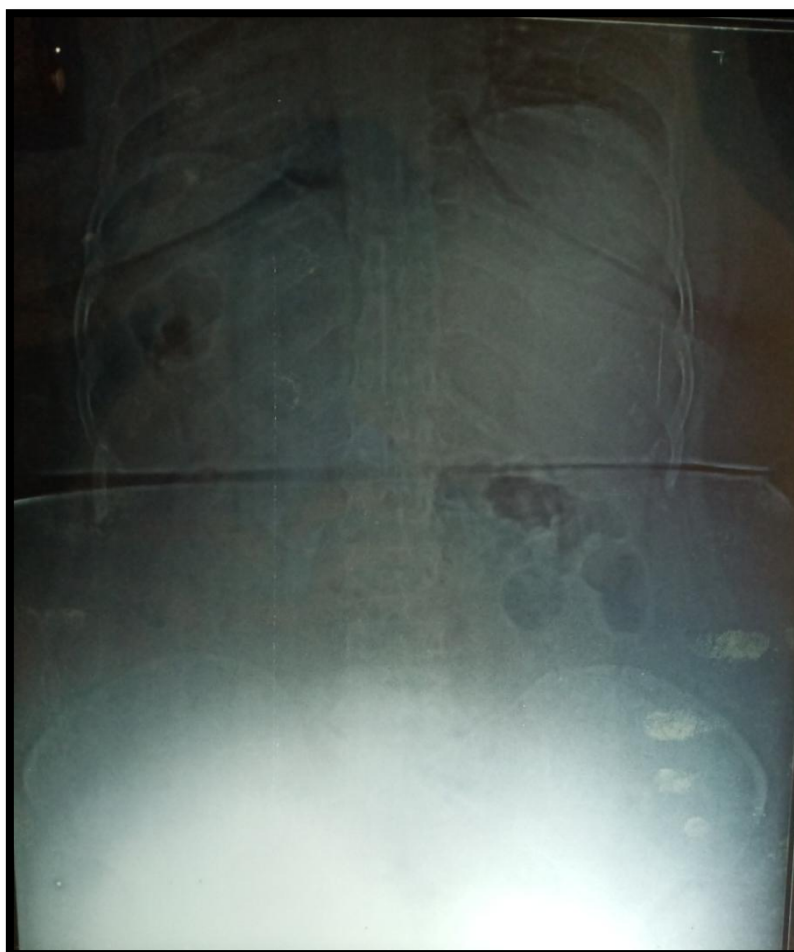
X-ray abdomen standing showing fundal gas shadow on right
